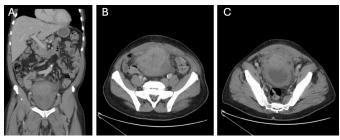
(A–C) Coronal view of computed tomography (CT) scan showing an 11 centimeter (cm) anterior pelvic mass abutting the bladder as well as diffuse bladder wall thickening from June 2023 (A). Axial views of CT scan revealing 11 cm pelvic mass that is contiguous with the umbilicus and abutting the bladder with diffuse bladder wall thickening (B and C).
